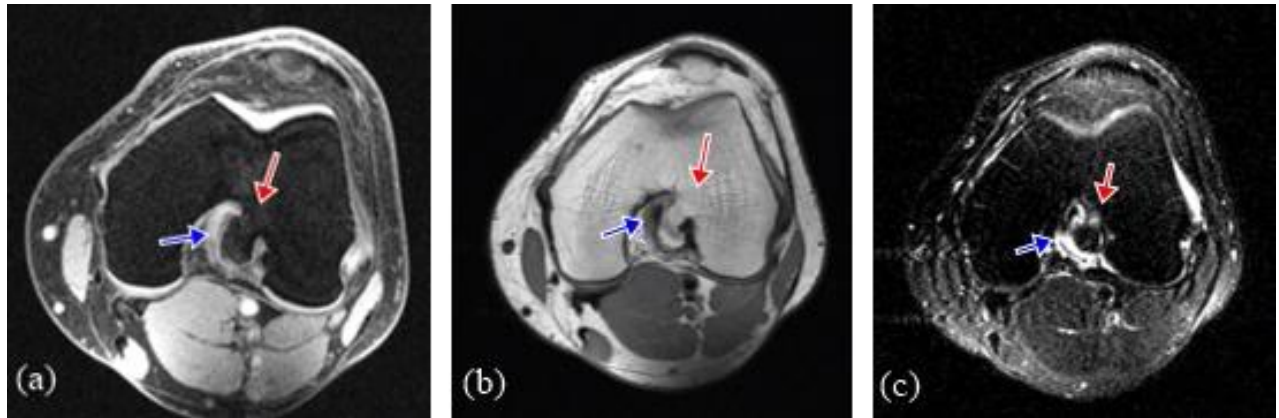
Axial magnetic resonance images (a, T2; b, PD; c, 3D SPGR FS) showing an intact stalk of the lesion (red arrow) and ACL impingement (blue arrow)
